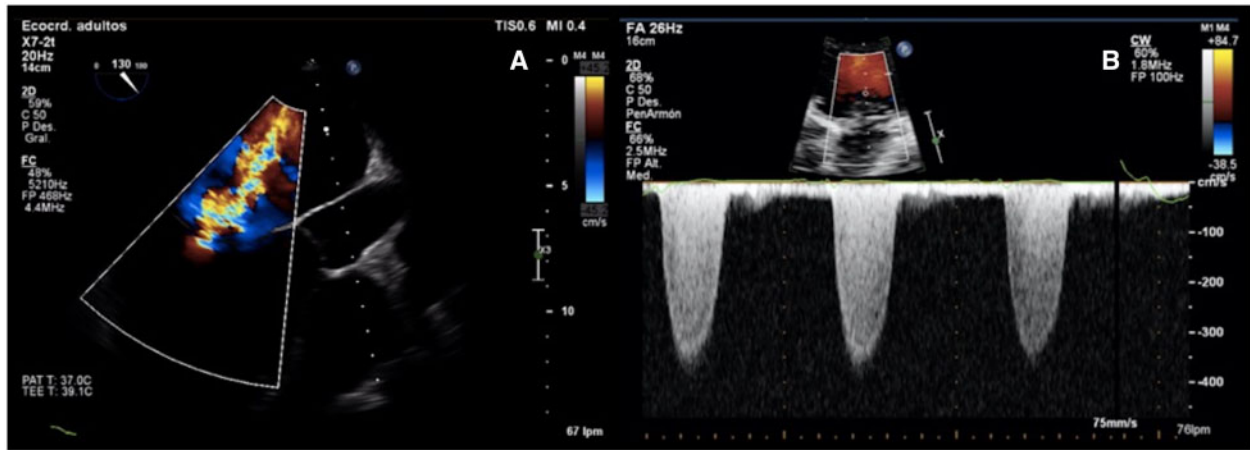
Transoesophageal projection at 130 degrees show mitral regurgitation jet (A); its evaluation with continuous Doppler reveals dense and triangular jet of low velocity due to ventricular dysfunction and atrial enlargement (B). Quantitative evaluation evidenced effective regurgitant orifice area of 0.42 cm², regurgitation volume of 42 mL, and end diastolic left ventricle volume of 131 mL/m²; assessed together were consistent with severe mitral regurgitation.
